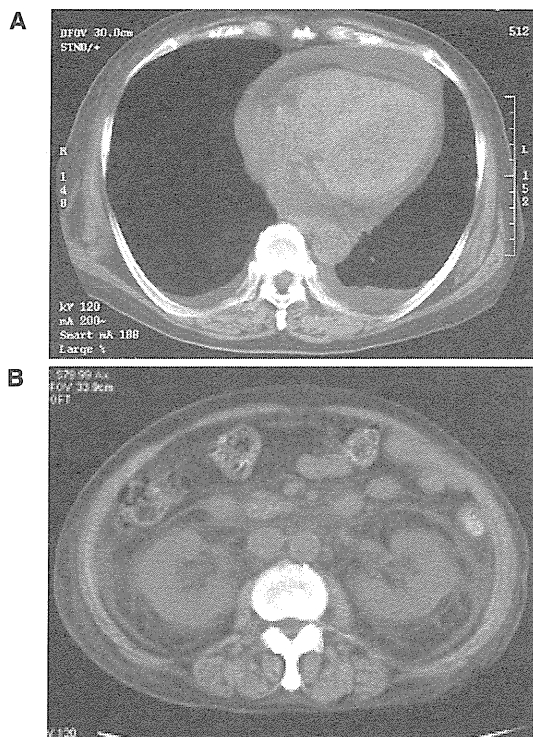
Chest and abdominal CT scans. (A) Pleural effusion and pericardial effusion were evident. (B) Bilateral and symmetrical perirenal soft tissue lesions were detected (“hairy kidney” appearance). A small amount of ascites was also present.
